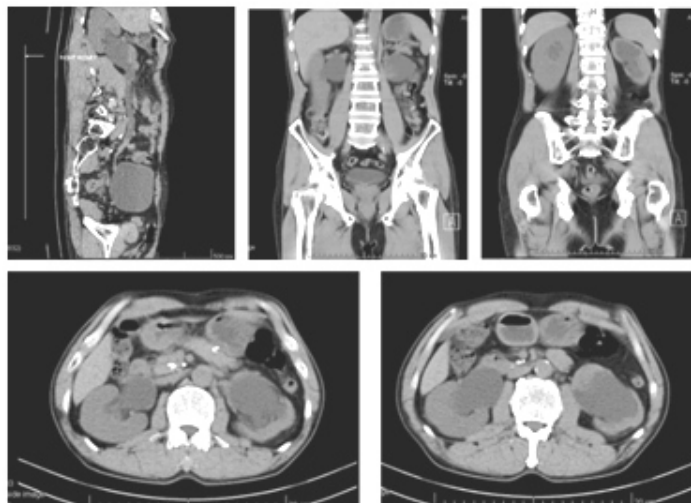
CT Scan on 21 July 2021 showed a bilateral tumor mass.
